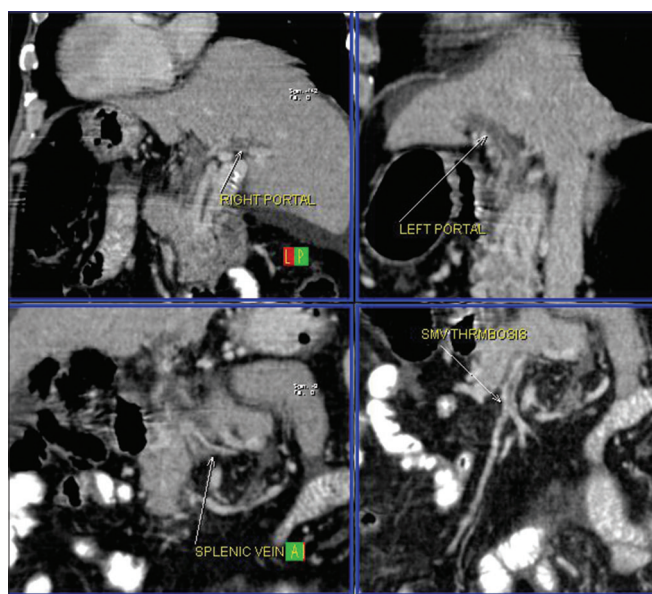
Contrast-enhanced computed tomography images show extension of thrombosis in superior mesenteric and splenic veins
